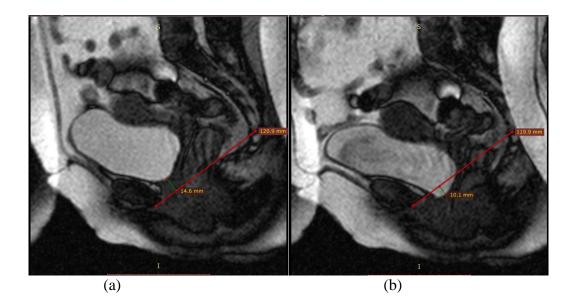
42-year-old female (a) sagittal BFFE MR image at rest and (b) at maximal strain show minimal bladder neck descent below pubococcygeal line
